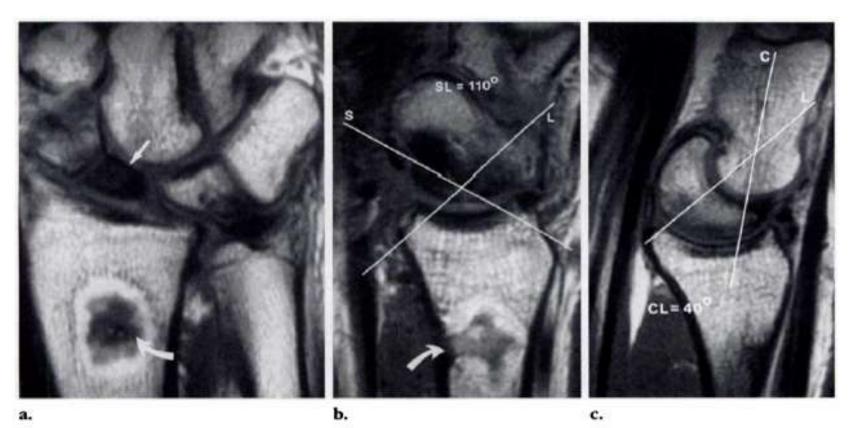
Unstable fracture of the scaphoid. C = axis of capitate, L = axis of lunate, S = axis of scaphoid.Coronal T1-weighted MR image (a) and sagittal T1-weighted MR images at the levels of the scaphoid (b) and thelunate (c) show an unstable scaphoid fracture with avascularity of the proximal pole. Note the low signal intensity of the proximal pole of the scaphoid (straight arrow in a) and the graft harvest site on the volar aspect ofthe radius (curved arrow in a and b). The scapholunate angle (*SL*) is greater than 60°, and the capitate-lunateangle (*CL*) is greater than 30°; these measurements are consistent with DISL.
